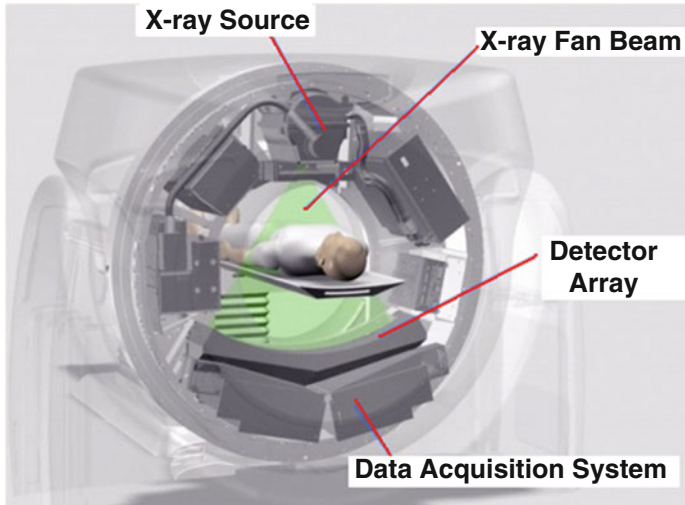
A typical CT machine showing various parts around a patient
